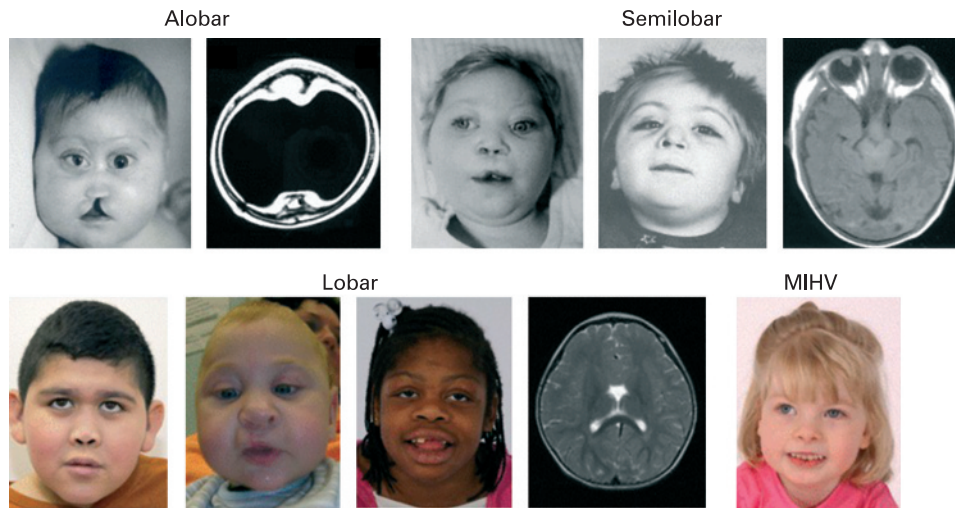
Patients with mutations in *SIX3*, arranged by HPE type (neuroimaging does not correspond with patients). All patients had point mutations in *SIX3* with the exception of the patient shown in the lower row, second from left, who had a complex cytogenetic rearrangement including deletion of 2p21. MRI on patients in row 2 courtesy of the Carter Centers.^{19–48} MIHV, middle interhemispheric variant.
